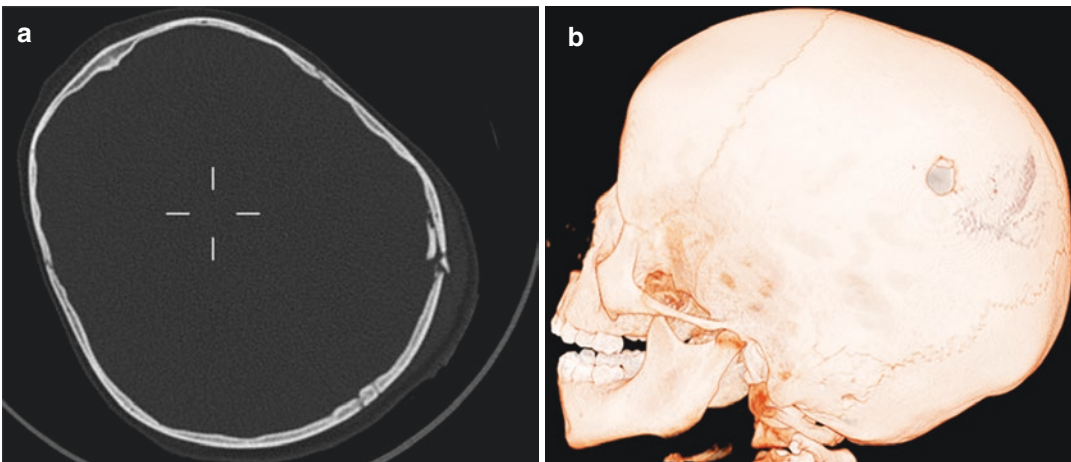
(a) Axial CT scan demonstrating a complex, depressed fracture of the left parietal bone. (b) 3D reformatted CT scan demonstrating the same complex, depressed fracture
